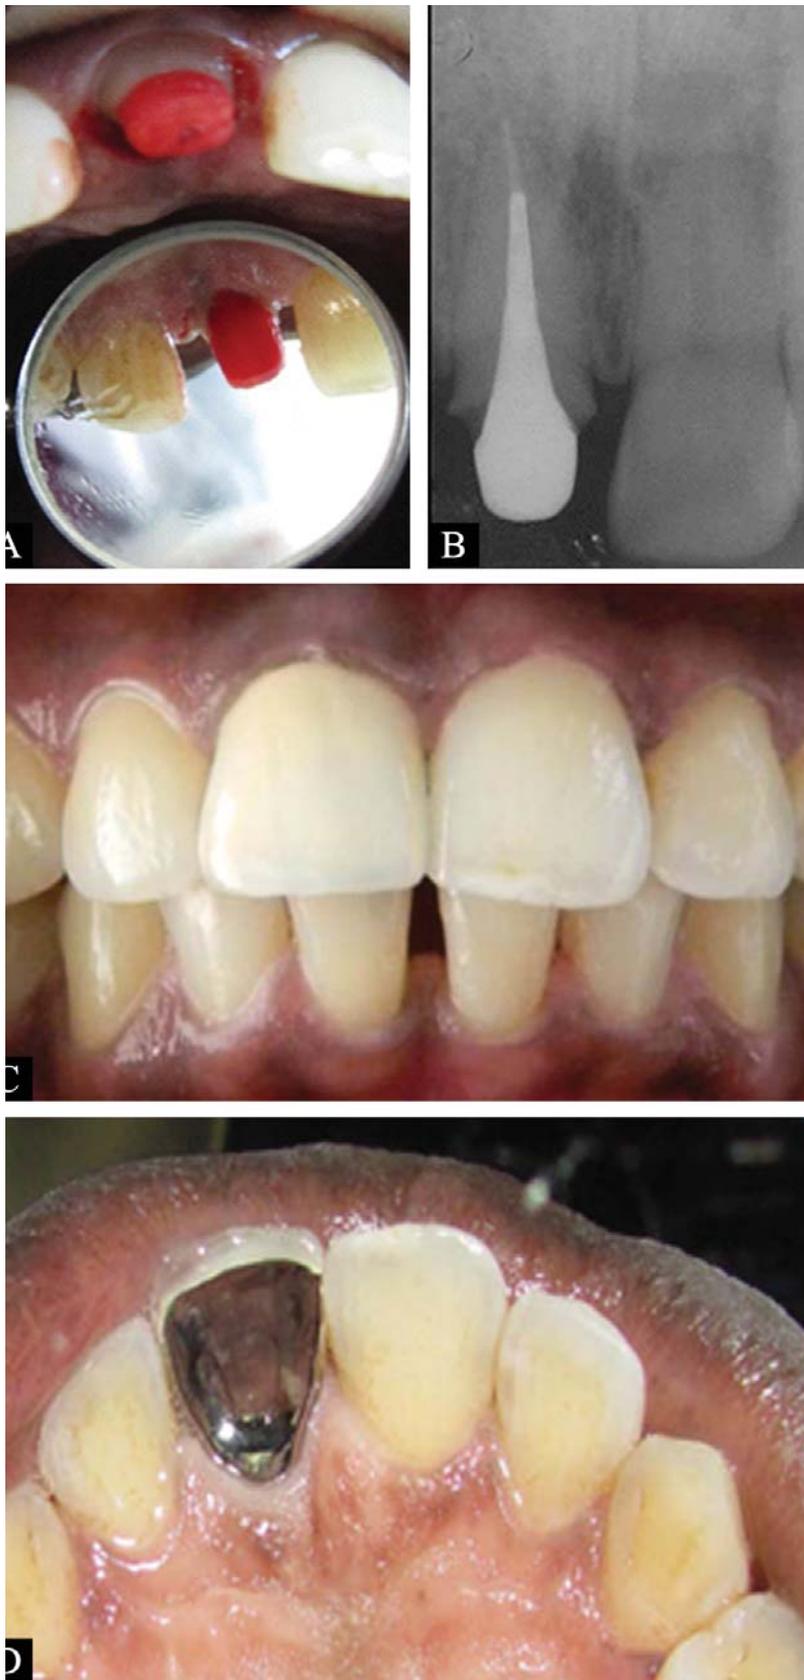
(A) Acrylic pattern of the post and core placed in the fractured tooth with indirect view of the palatal aspect. (B) Periapical radiograph taken after cementation of the cast post and core. (C) Frontal view of the fractured tooth following crown cementation. (D) Palatal view of the cemented crown (indirect image).
